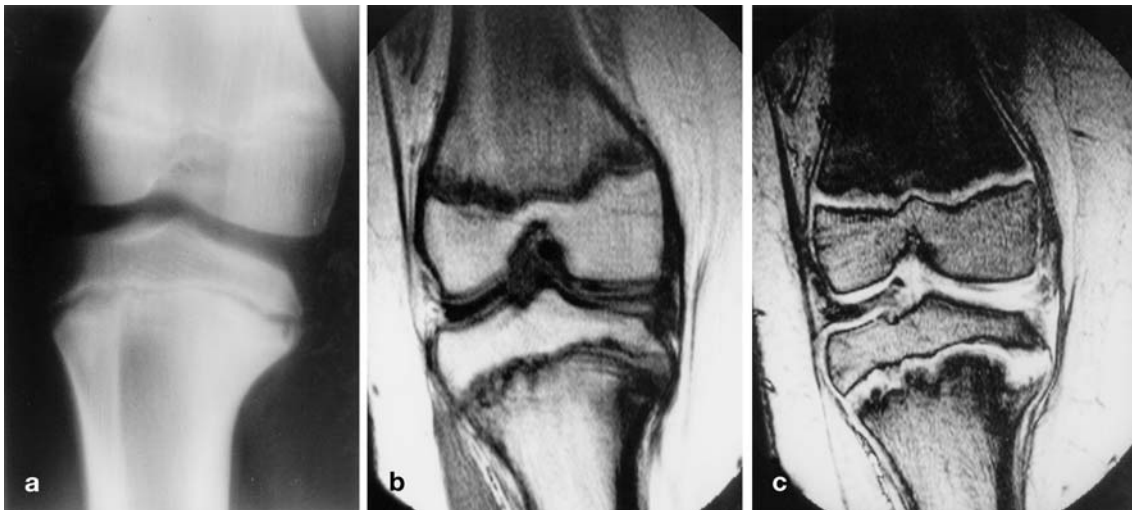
Severe tibia vara (bilateral) in a 12-year-old boy. a Varus angulation of the right tibia is seen on conventional anteroposterior tomogram. The tibial growth plate is widened and irregular in the medial and lateral metaphysis. To a lesser extent, similar findings are present in the femoral growth plate. b T1-weighted images (650/20) of the right knee show severe flattening of the medial tibial epiphysis. The tibial growth plates are wide, irregular, and show mixed signal intensity. The same signal intensity is observed in the lateral femoral growth plate. Decreased signal is noted in the deformed medial tibial metaphysis. c Gradient echo images (700/20, 40°) better demonstrate the abnormality at the tibial epiphysis. Note the invaginations of cartilage into the tibial metaphysis that account for part of the decreased signal on the T1-weighted sequences. The wide tibial physal involvement is clearly visible in both the medial and lateral half, while the femoral involvement affects mostly the lateral aspect of the physis
